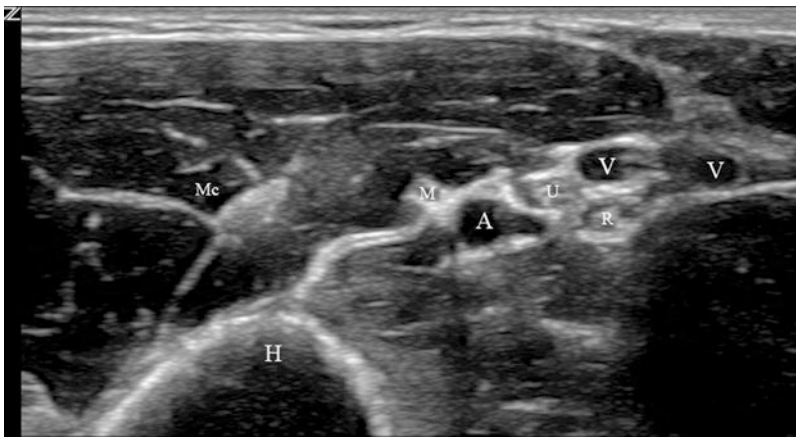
Ultrasonographic appearance of nerves in the humeral canal (A brachial artery, H humerus, M median nerve, Mc musculocutaneous nerve, R radial nerve, U ulnar nerve, V brachial vein)
